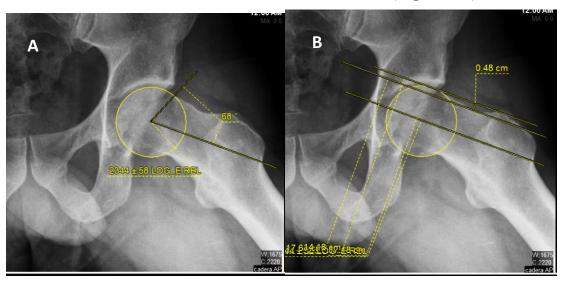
detailed radiograph of left hip in Dunn 45° view showing, A. measurement of the alpha angle (68°), and B. measurement of the H-N offset (4.8mm)
